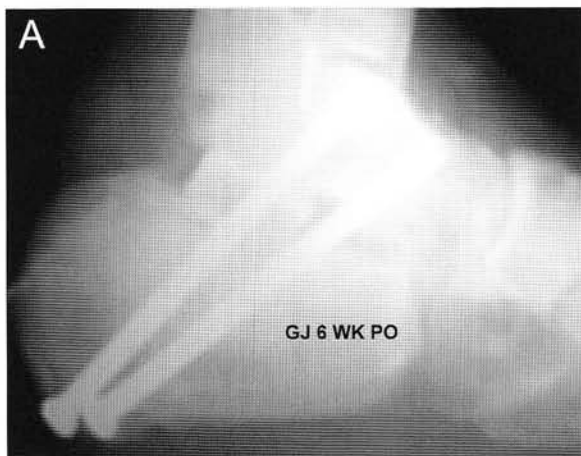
Series of x-rays between 6 weeks and 7 months revealing continued incorporation and healing of the subtalar joint fusion site. Note an increase in hindfoot height of 4 mm from preoperative level. The patient is fully weightbearing and expected to return to work at this point.
